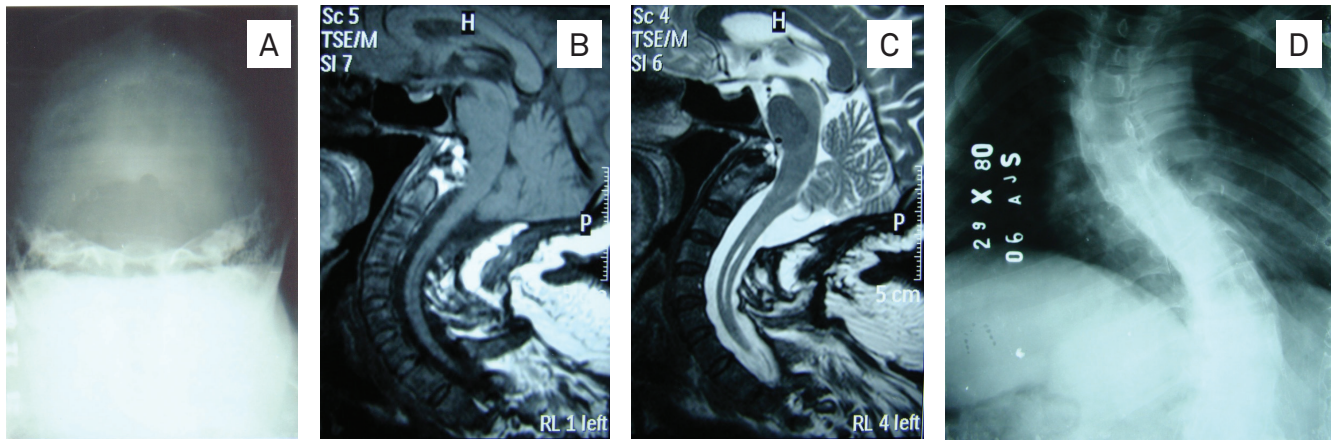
(A) Skull x-ray showing large craniectomy of the posterior fossa. (B) Preoperative MRI depicting hindbrain herniation and enlargement of the spinal canal. (C) Postoperative MRI showing a large artificial cisterna magna. (D) X-ray depicting thoracic and lumbar scoliosis.
